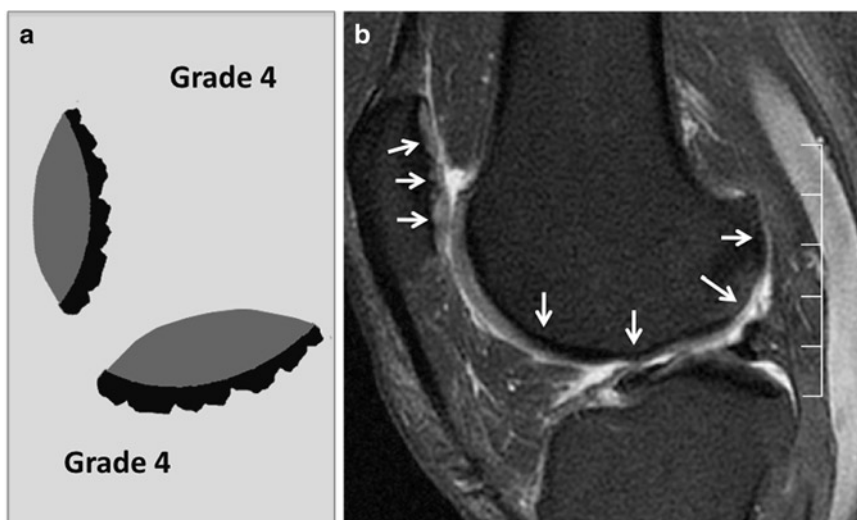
Whole-Organ-MRI-Score (WORMS) grade 4.* Graph of grade 4 knee cartilage lesions (a) and sagittal fat saturated intermediate weighted fast spin echo sequence of the knee (b) showing cartilage WORMS grade 4 lesions at the patella, the central, and posterior portion of the lateral femoral condyle. The lesions affect more than 75% of the joint surfaces and are
